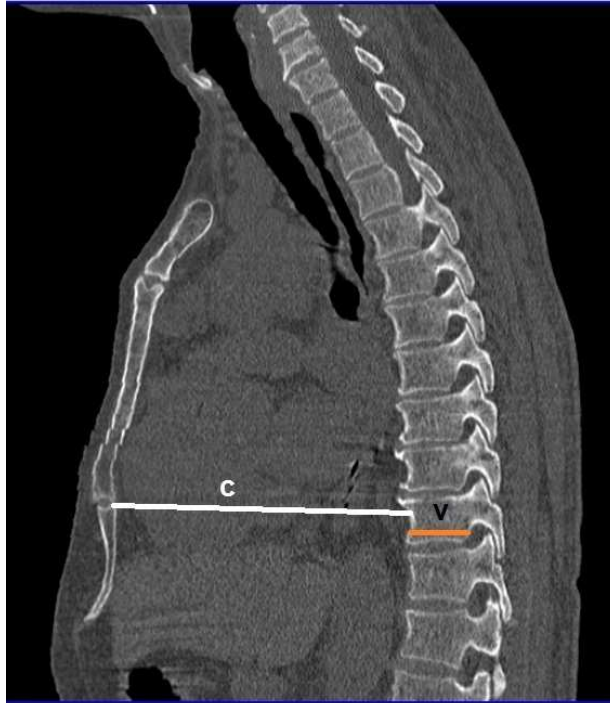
Non contrast CT image(sagittal view) of thorax showing the measurement of vertebral index
